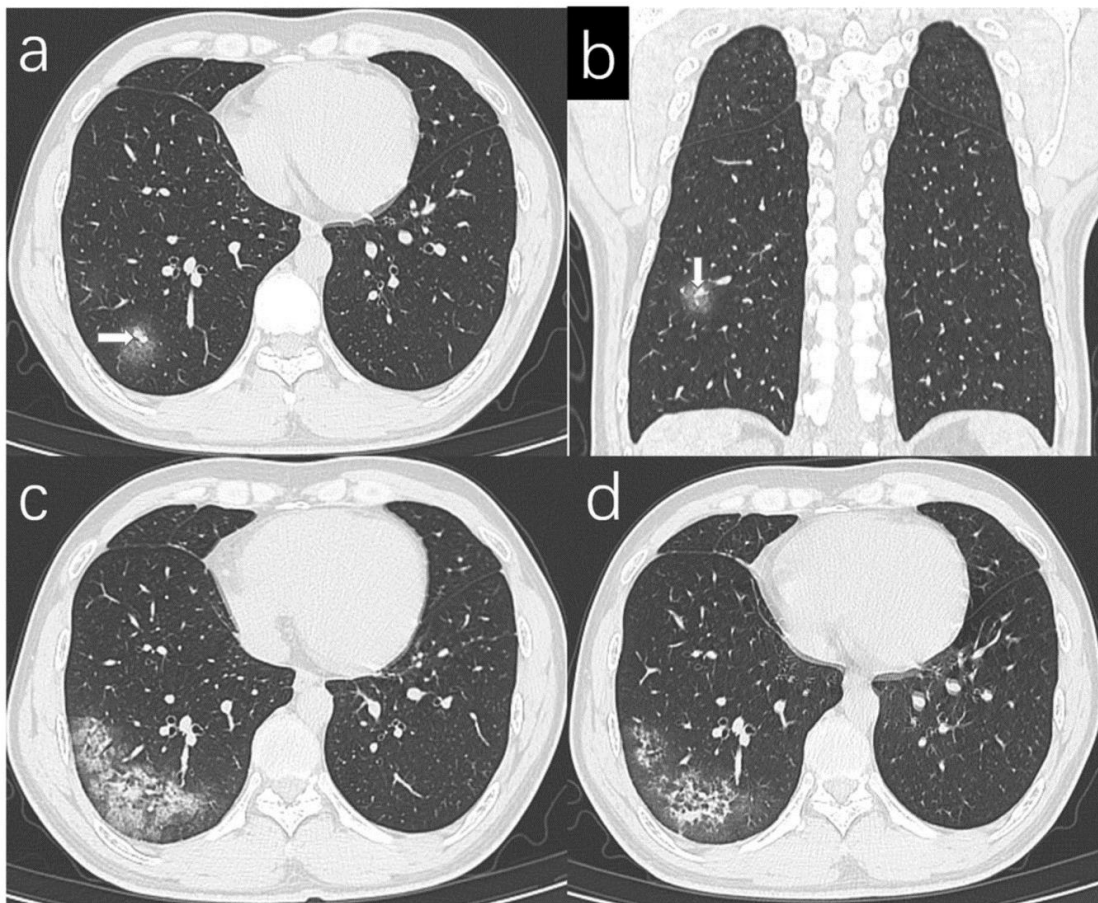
A 29-year-old woman with COVID-19 pneumonia. a, b Axial CT image and coronal CT image showed ground-glass opacification accompanied with thickened small vessels (arrow) in the right lower lobe on day nine after symptom onset; c The first follow-up CT image (5 days after initial CT) showed the ground-glass opacification obviously enlarged mixed with consolidation. d The second follow-up CT image showed the opacification gradually absorbed and the density of the lesion reduced. (41)
